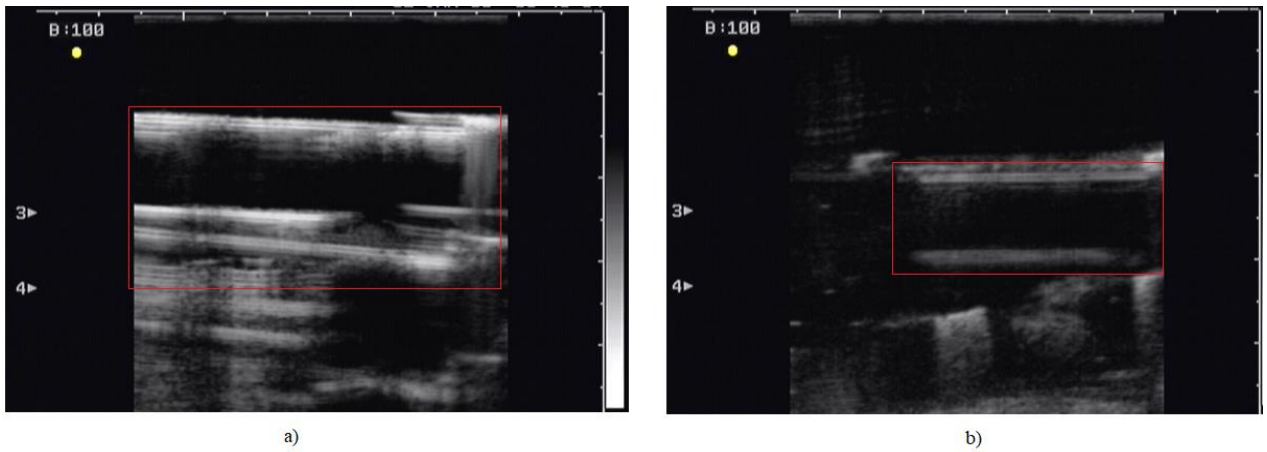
With 7.5 MHz linear transducer acquired ultrasound images of samples irradiated with 0.5 Gy (a) and 2 Gy (b) dose.
